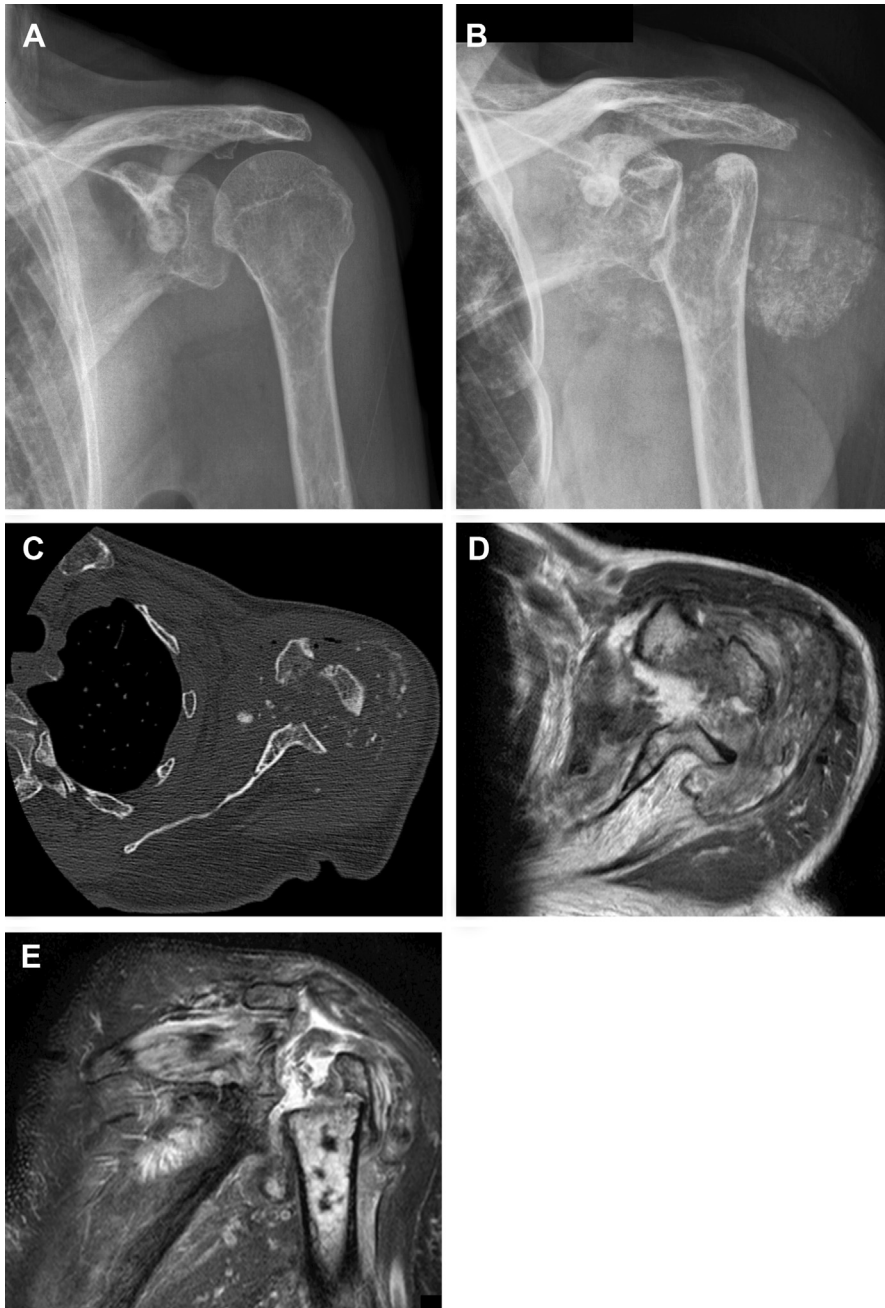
Milwaukee shoulder syndrome. Posttraumatic left shoulder (A) of an 80-year-old woman without fracture and preexisting rotator cuff pathology. After 6 weeks (B) complete destruction of the humeral head and a large soft tissue mass with multiple bony fragments is seen. Axial CT image (C), T1TSE (D), and coronal T2fatsat MR images (E) show complete humeral head destruction with several bony fragments, surrounded by fluid and debris, extending into the subacromial bursa secondary to rotator cuff pathology.
